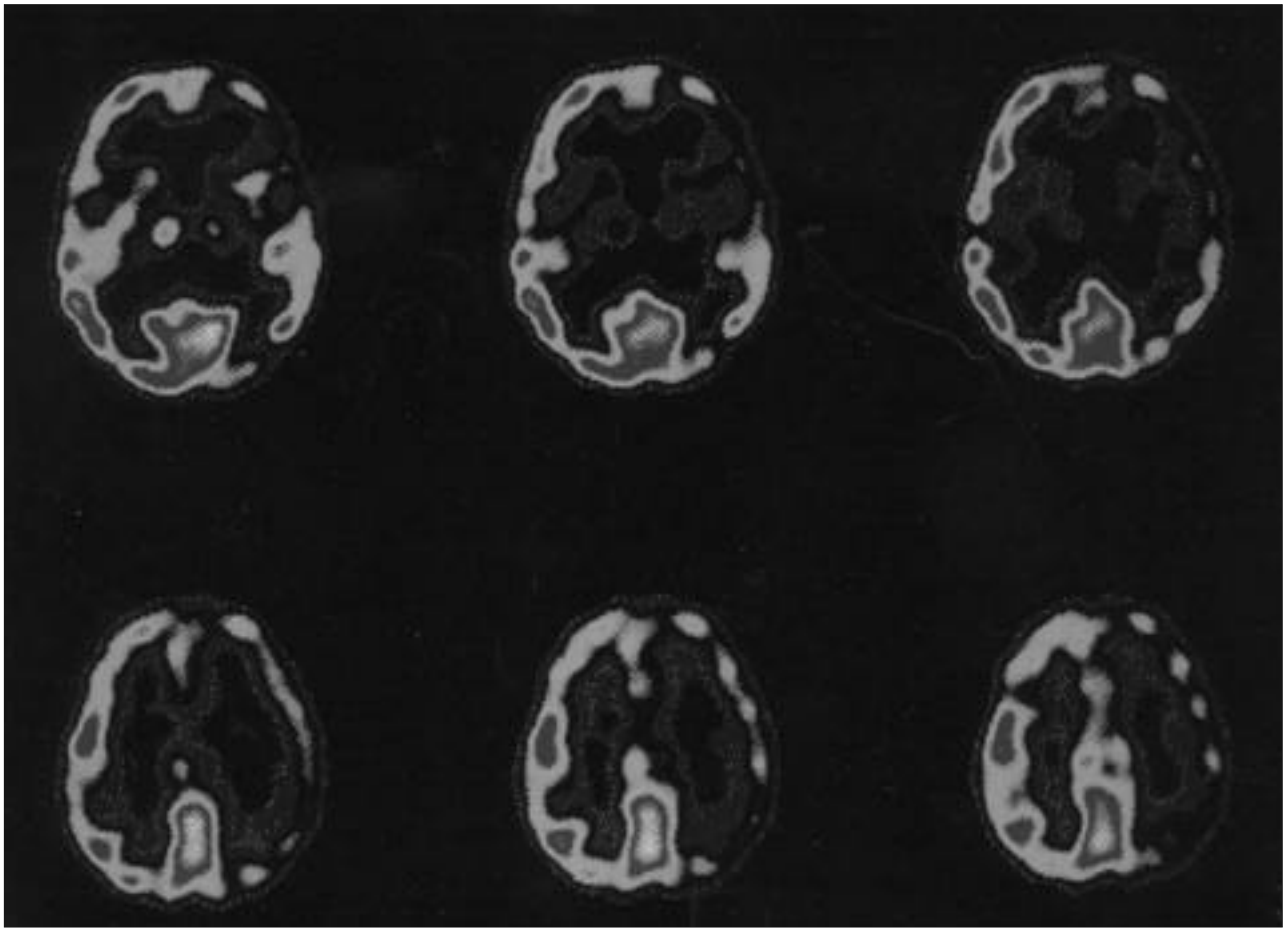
SPECT findings: Compared to MRI findings shows marked decreased perfusion in the case of lacunar syndrome with middle cerebral artery occlusive lesion
